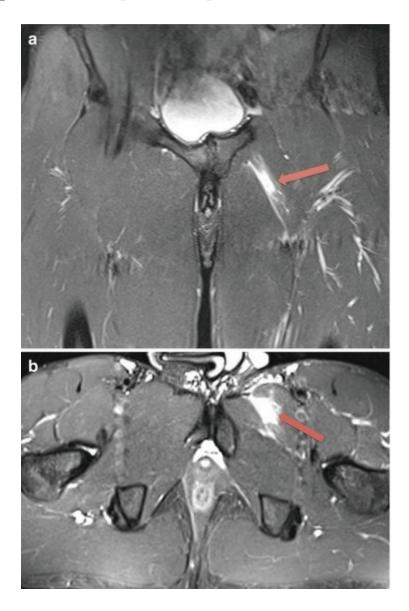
A 28-year-old male athlete with an injury to the myotendinous junction of the left adductor longus (AL). (a) Coronal and (b) axial short tau inversion recovery MRI show intrasubstance high signal intensity (*arrow*) at the proximal portion of the left AL, distant from its osseous attachment, consistent with an injury to the myotendinous junction
